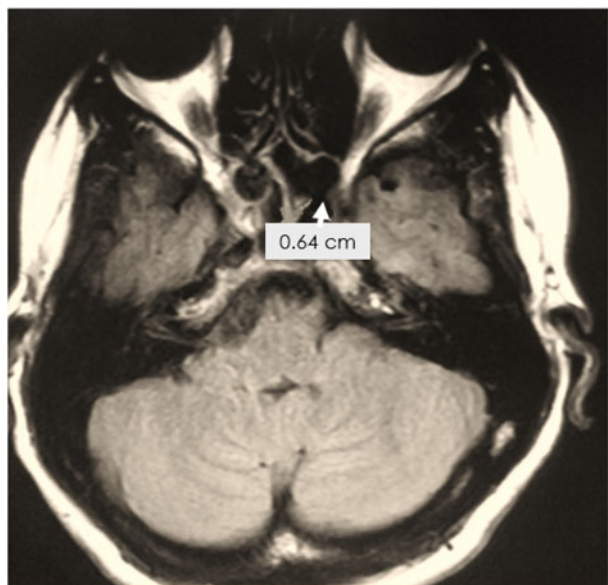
Axial plane T2-weighted magnetic resonance image showing a defect in the lateral recess of the sphenoid.
